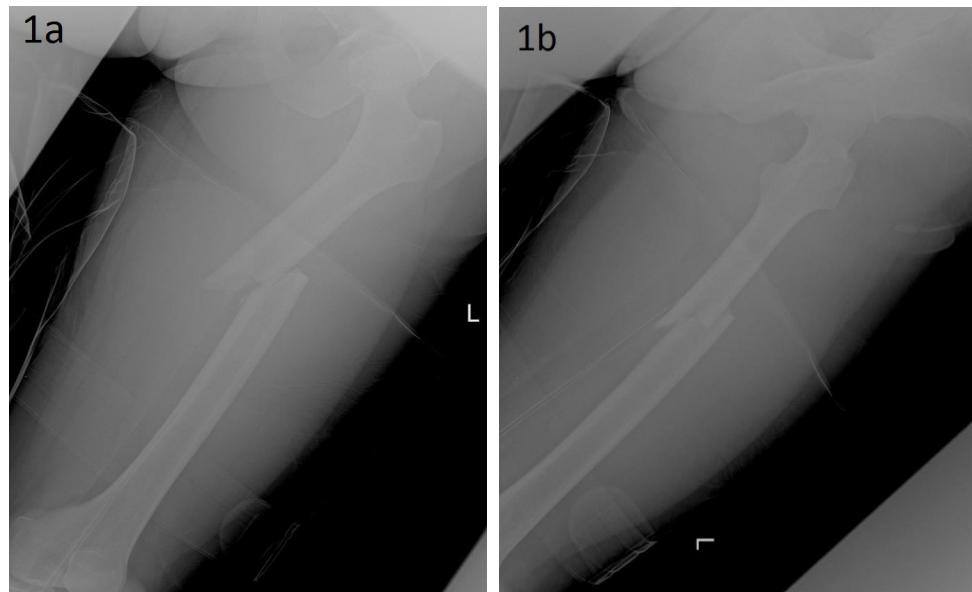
Radiograph AP (1a) and lateral view (1b) of left femur showing fracture of mid-shaft femur
